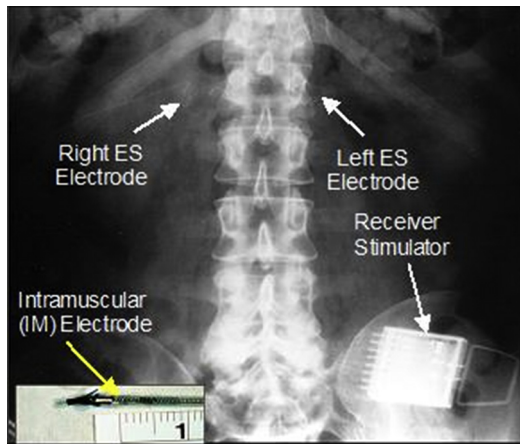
Radiograph of an implanted trunk system showing intramuscular electrodes (*inset*) inserted into T12-L1 to activate the lumbar erector spinae muscles.
